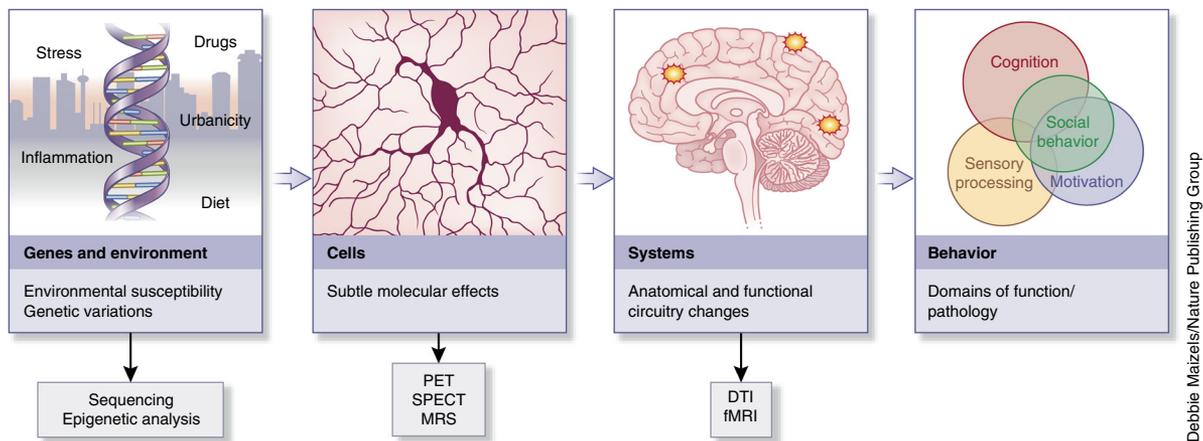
Genetic and imaging biomarkers. Imaging biomarkers can be cell- or circuit-based, imaged with MRI or PET modalities and represent intermediate biomarkers between genes and various domains of behavior. Adapted, with permission, from Figure 1 in Birnbaum, R. & Weinberger, D.R. Functional neuroimaging and schizophrenia: a view towards effective connectivity modeling and polygenic risk. *Dialogues Clin Neurosci.* 15, 279–289 (2013). (*Dialogues in Clinical Neuroscience*, © Institut La Conférence Hippocrate, Suresnes, France.)
